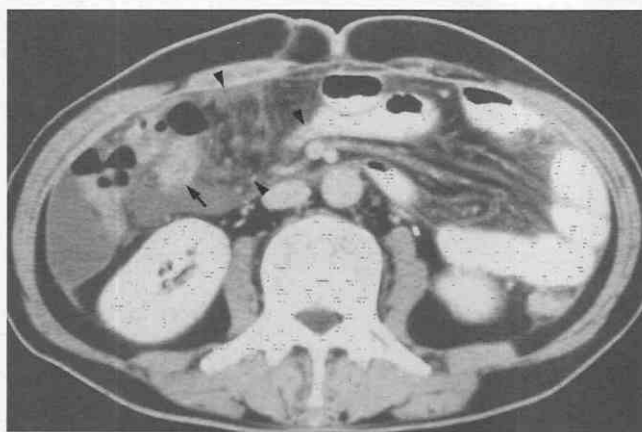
Behçet's syndrome with bowel perforation. CT scan shows intraperitoneal fluid collection and mesenteric infiltration (arrowheads) surrounding the involved bowel loop (arrow). (From Ha HK, Lee SH, Rha SE, et al: Radiologic features of vasculitis involving the gastrointestinal tract. *Radiographics* 20:779-794, 2000.)
